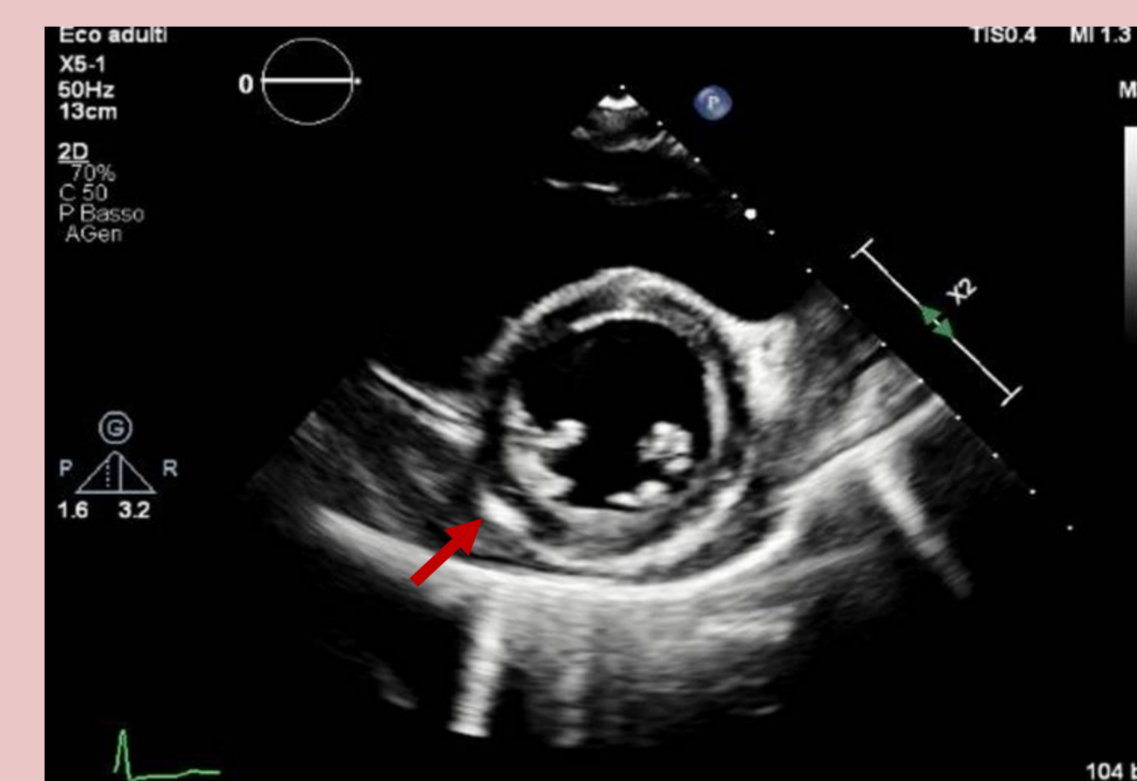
Transthoracic echocardiography
